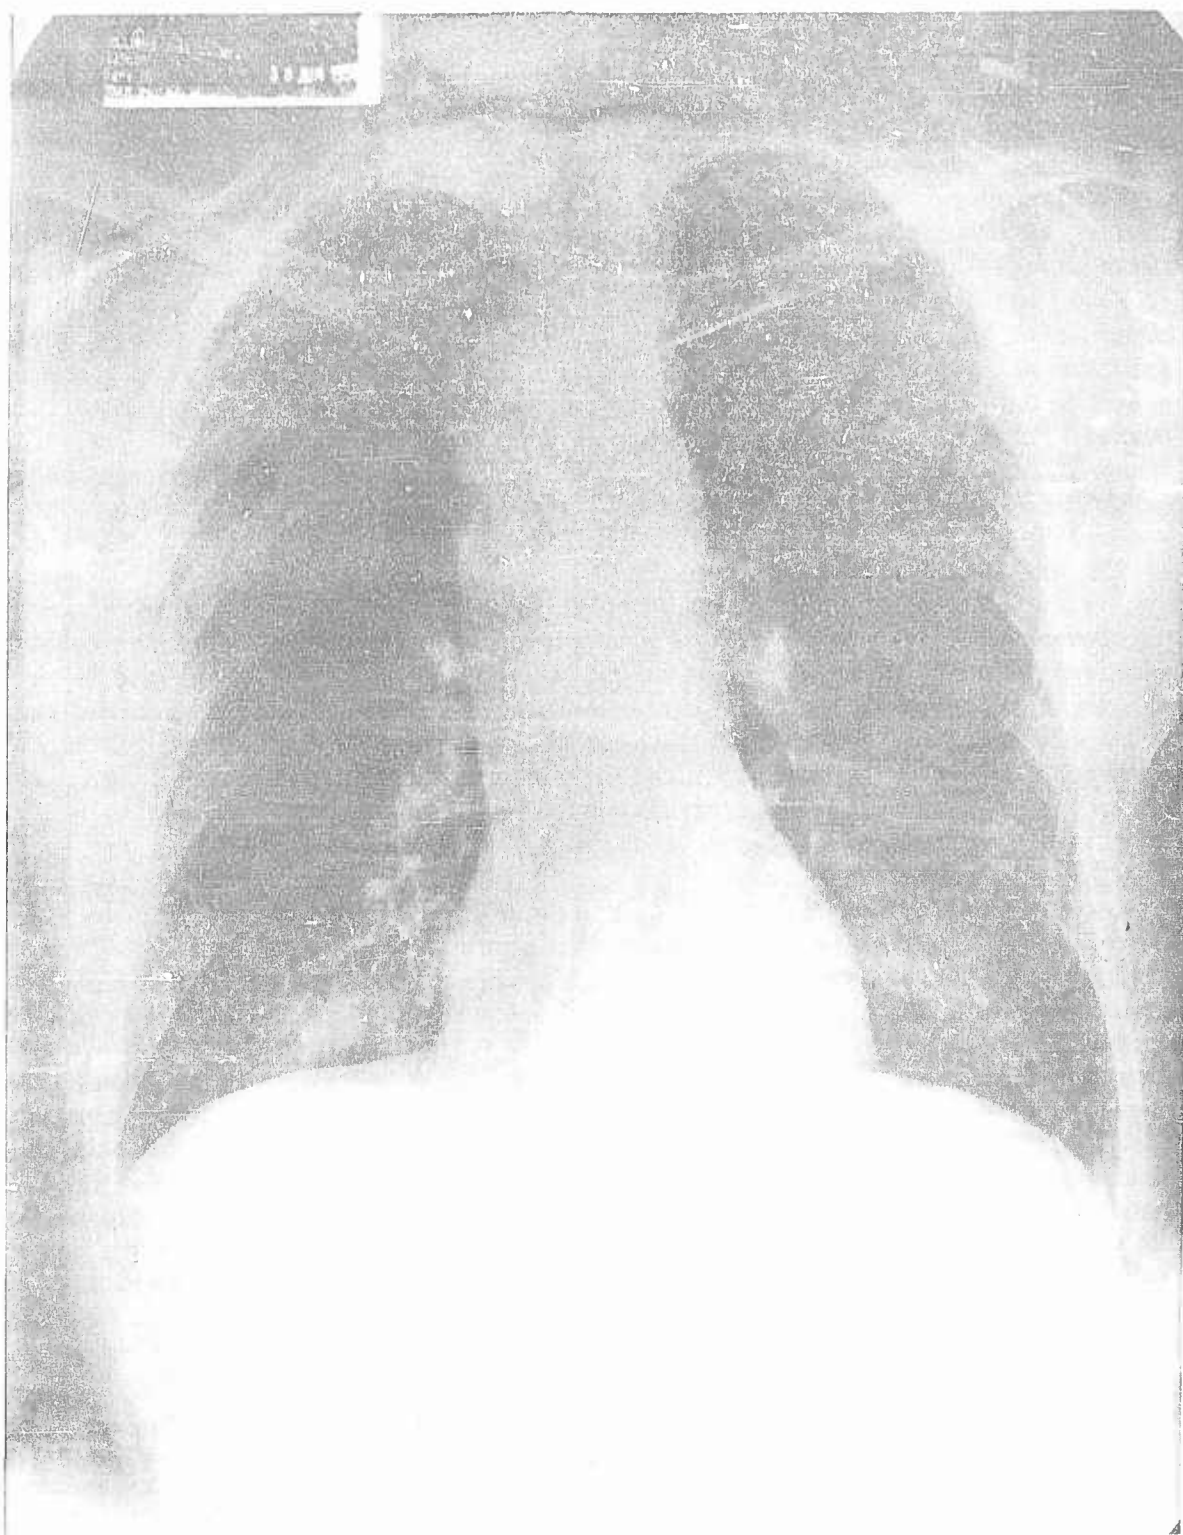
ADMISSION CHEST X-RAY DAY 2 OF DISEASE.
